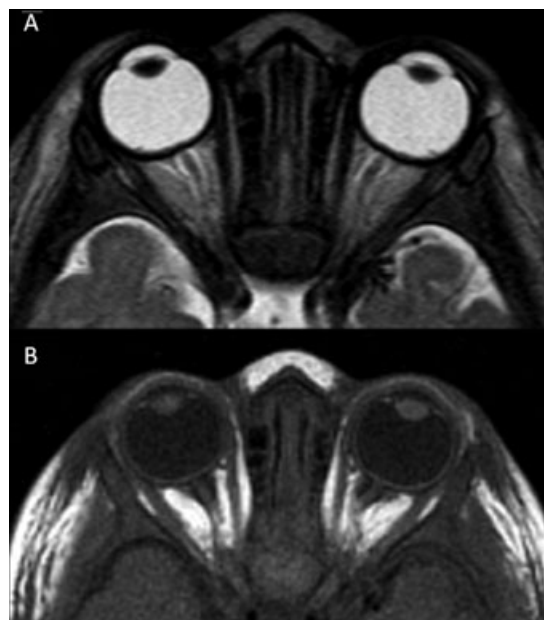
High resolution T2 (A) and T1-weighted (B) orbital MRI may directly show posttraumatic retinal hemorrhages related to vigorous shaking of a newborn. These findings may render valuable, additional evidence suggesting nonaccidental injury.
